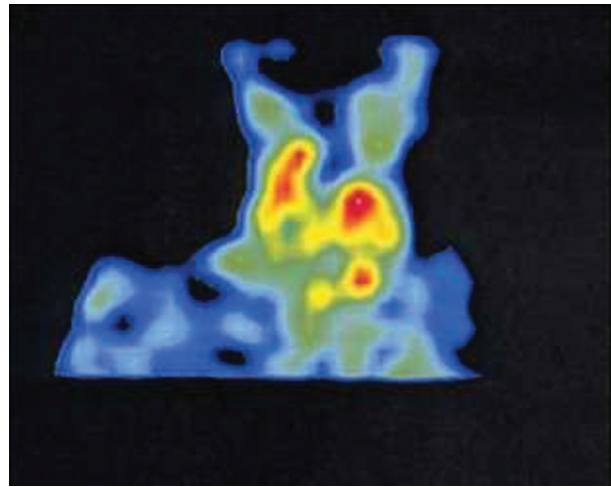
Coronal SPECT [^{111}In]pentetreotide image showing extensive somatostatin positive uptake in lymph nodes invaded by medullary cell cancer of the thyroid (the red areas are the cancer). These were treated by surgery and radiotherapy.
